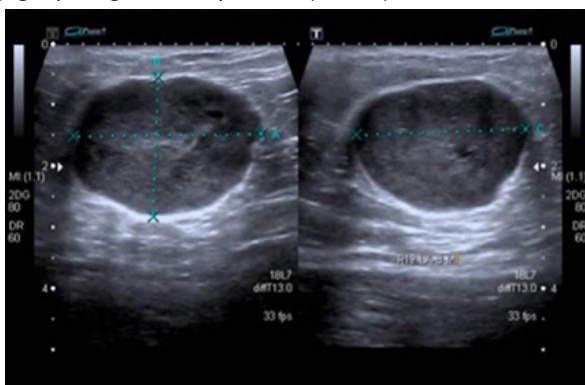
Left breast nodule ultrasonography, reveals a heterogeneous, avascular lesion located at 1:00 and 2:00 o'clock radius, line b.
